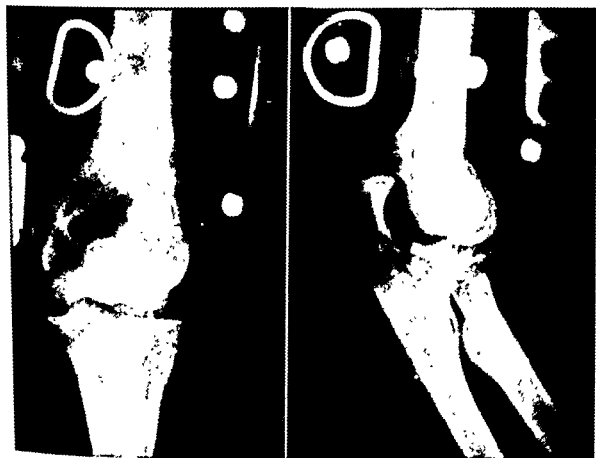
(Left) Roentgenogram, anteroposterior view, showing a comminuted fracture of the head of the radius and the olecranon process. (Right) The same elbow, lateral view. Note dislocation of the elbow.
